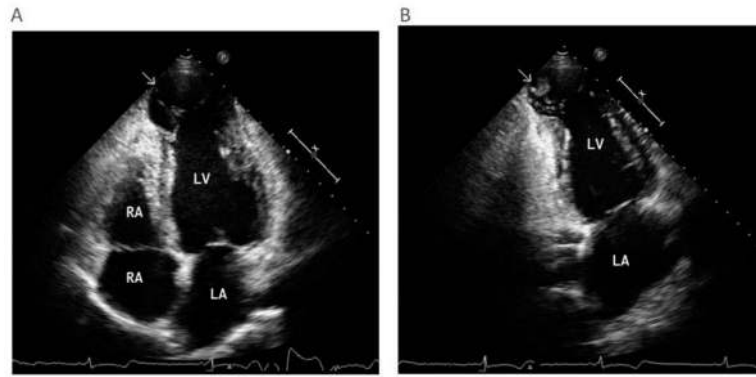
Echocardiography of a patient with chronic chagas cardiomyopathy
